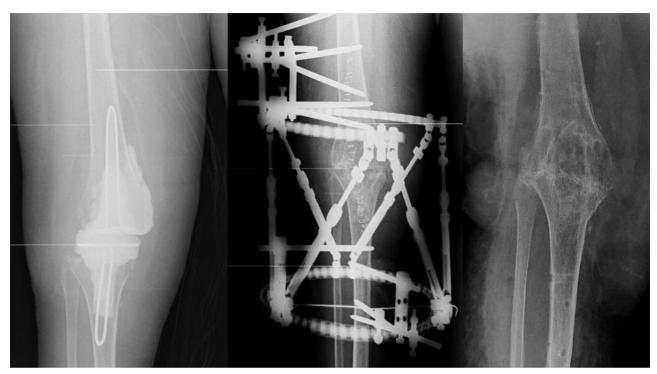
X-ray images before arthrodesis, after Ca-CEF application and after fixator removal are seen
